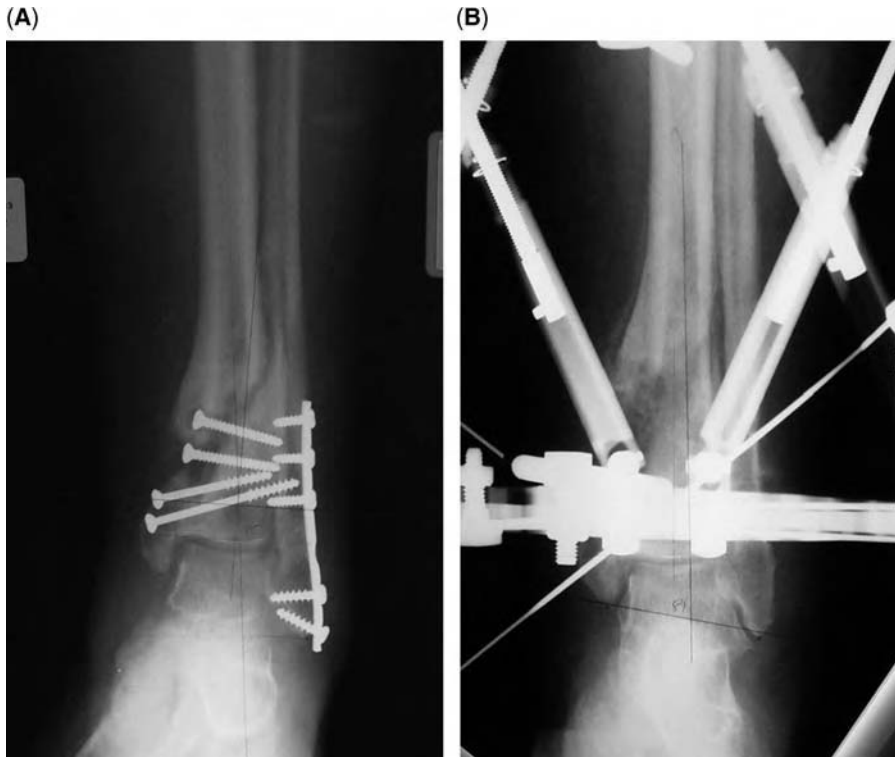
(A) Anteroposterior radiograph showing relative shortening of the tibia and a nonunion. (B) After gradual lengthening and deformity correction of the tibia with an Ilizarov/Taylor spatial frame.
